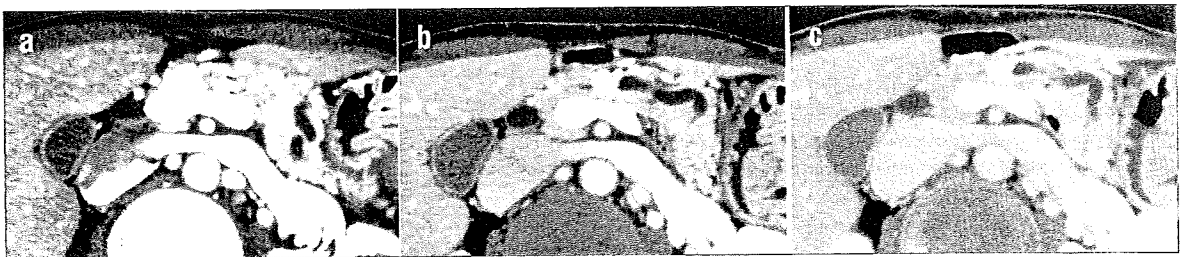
Multidetector CT shows a hypoenhancing mass at the pancreatic phase 40 sec after contrast administration (a). However, it showed homogeneous contrast enhancement at the portal phase, 80 sec after contrast administration (b), and the enhancement lasted until the late phase, 180 sec after contrast administration (c).
